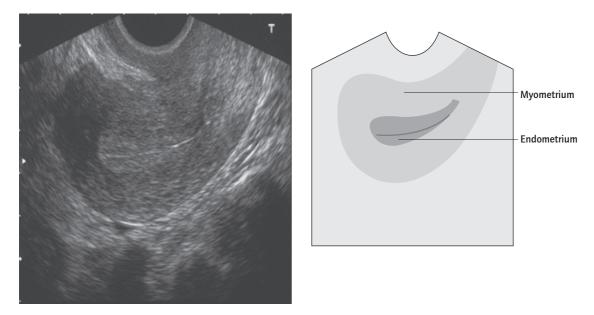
Transvaginal ultrasound of a normal uterus and mid-cycle endometrium.
